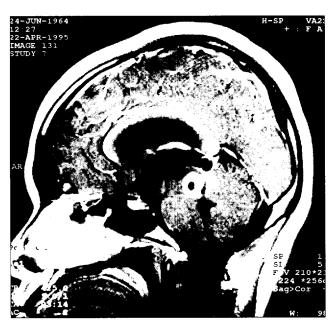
Tuberculoma with ring enhancement in the midbrain region on T1-weighted image after injection of IV gadolinium
